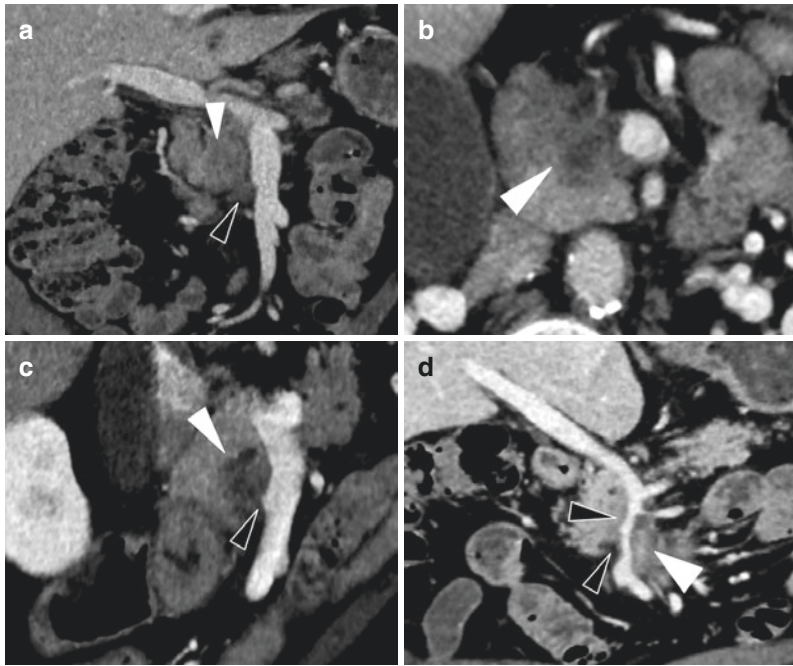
Example of CT images showing arterial invasion by the tumor. CT with contrast injection at the pancreatic arterial phase, axial (a, c, and e) and coronal (b, d, and f) views showing different types of arterial involvement: (a and b) no arterial involvement by a tumor in the distal femoral head (white arrowheads), at a distance from the superior mesenteric artery. (c and d) Arterial contact $<180^\circ$ with no change in arterial caliber; tumor in the head of the pancreas (white arrowheads) with focal contact with the origin of the common hepatic artery (white arrows) circumferential arterial encasement of the superior mesenteric artery (black arrows) by a hypoattenuating tumor in the lower part of the pancreatic head
